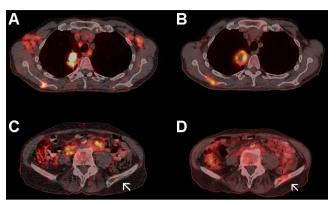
Positron emission tomography-computed tomography (PET/ CT) in a 70-year-old man with a history of DLBCL 3 years ago. A, C) Transaxial fused PET-CT images show lymphadenopathy with limited F-FDG uptake (SUVmax 3.2) and (A) tumor formation in the right lung with intensive glucose metabolism (SUVmax 12.2) – highly suspicious for two different primary tumors. Biopsy confirmed the diagnosis of synchronous primary malignancies – indolent lymphoma and lung cancer. The restaging PET/CT (B, D) showed the complete metabolic response for indolent lymphoma, but the progression of the other malignant tumor-raising metabolic activity in the primary lung cancer and new bone lesions.
